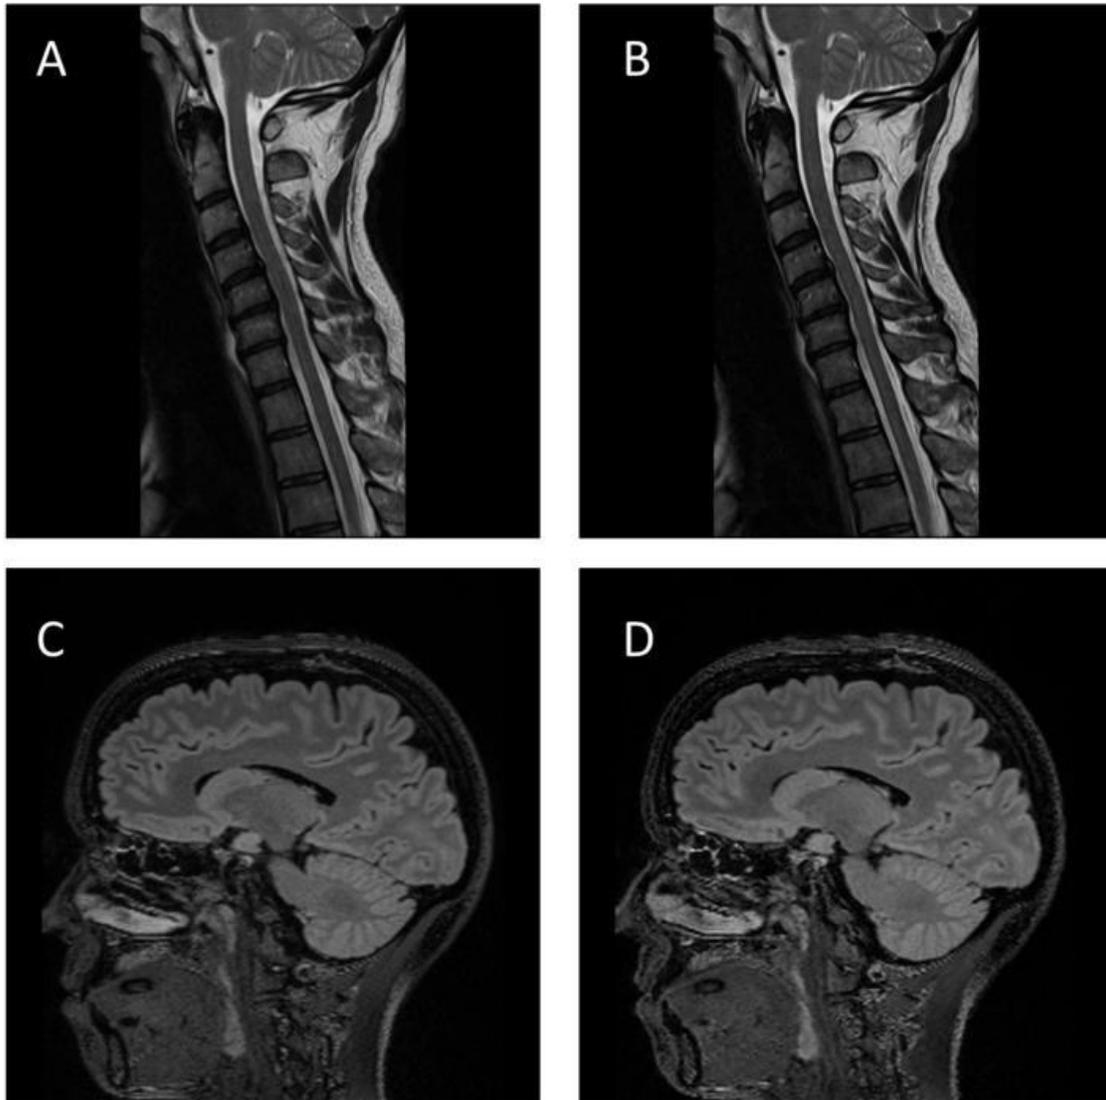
Conventional and processed-short protocols of cervical spine and brain 1.5T imaging. Conventional cervical spine T2w imaging (A) and brain T2 FLAIR 3D imaging (C) and the corresponding processed-short protocol variants (B and D, respectively), demonstrating comparable image quality and diagnostic suitability. Scan time of variants was reduced by 32% for cervical spine and 29% for brain.
